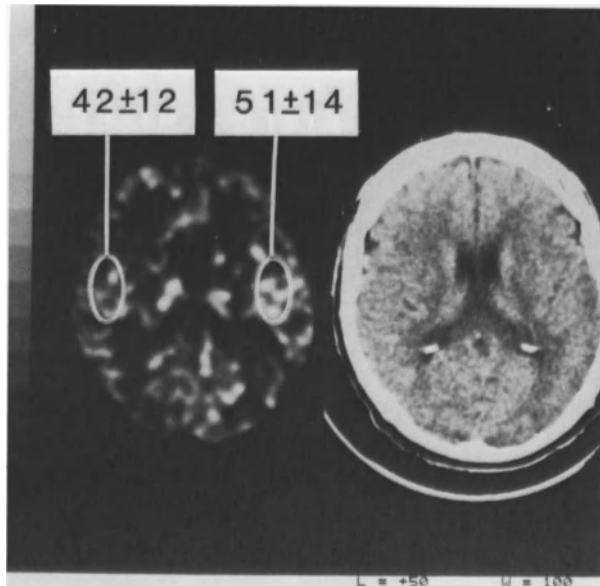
a. This 58-year-old man had sustained a right hemispheric stroke two months earlier probably at the time of ipsilateral ICA occlusion. The CT scan suggests a small internal capsule lesion on the right side and the accompanying CBF study shows a moderate reduction of right hemispheric flow values compared to the left side
